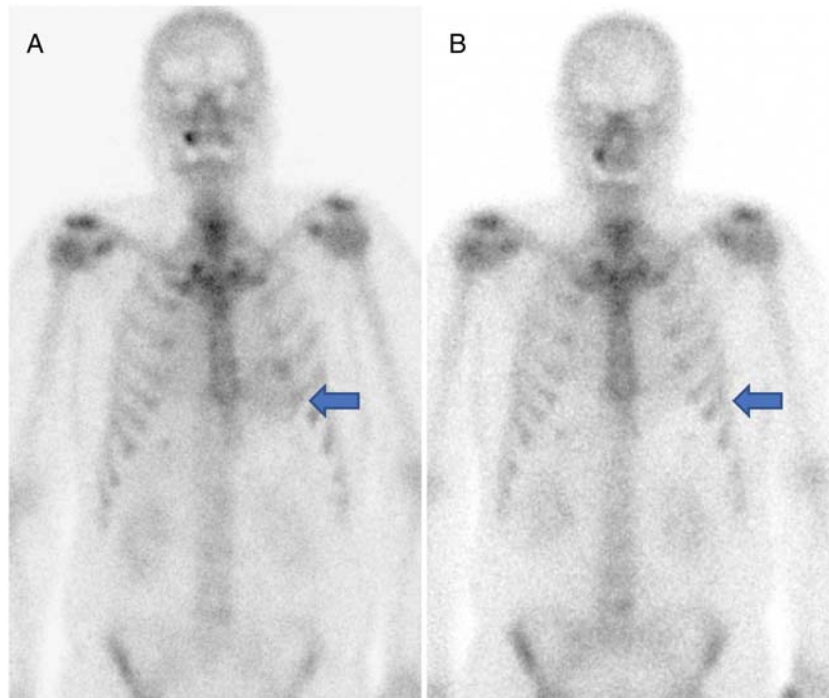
99m-Tc DPD/HDP bone scintigraphy 4 days after myocardial infarction shows a myocardial tracer uptake Perugini Score 2 (blue arrow) (A). Three months after myocardial infarction, scintigraphy does not show any cardiac uptake of technetium (B).
